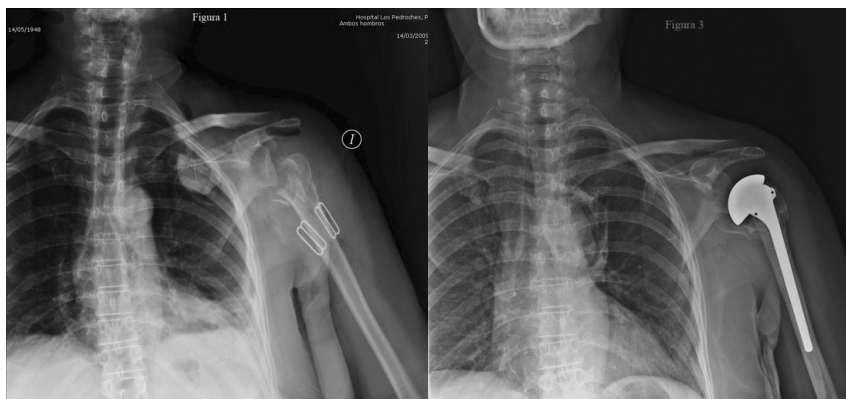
Left: plain chest X-ray showing scapulohumeral fracture and dislocation with a humeral fragment displaced into the chest. Right: Plain chest X-ray showing left shoulder arthroplasty.
